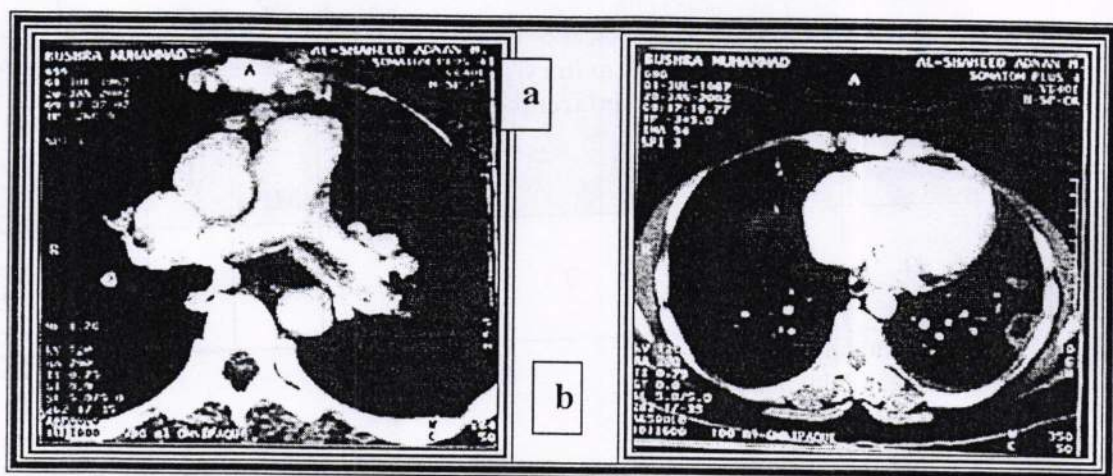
Pulmonary Embolism . CTPA showing bilateral filling defects within the main pulmonary arteries (a), native CT showing LT-sided peripheral wedge-shaped cavitory pulmonary infarct (b).
